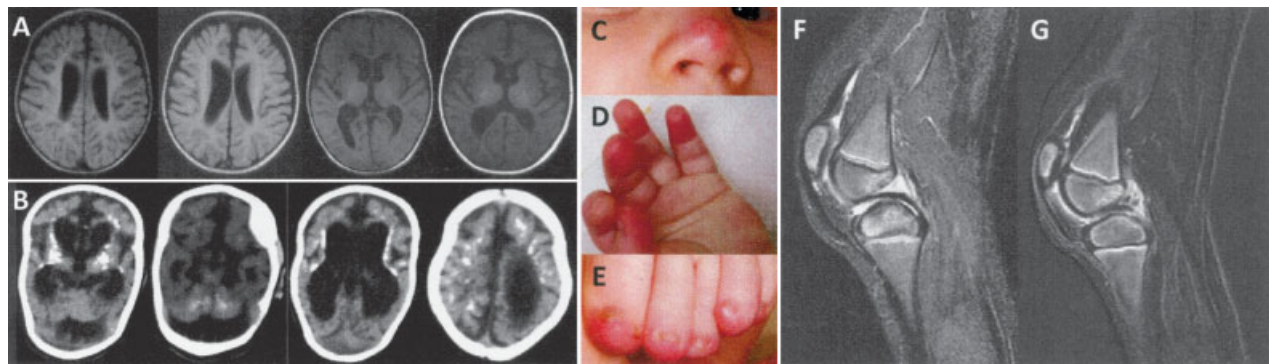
Imaging findings and cutaneous signs in patients with Aicardi-Goutières syndrome (AGS). A, Magnetic resonance imaging of an AGS patient with mutations in ribonuclease H2 subunit C (*RNASEH2C*)/AGS3 (patient 13), showing extensive white matter abnormalities with an anteroposterior gradient, in addition to cortical atrophy. B, Computed tomography imaging of an AGS patient with *RNASEH2A*/AGS4 (patient 16), demonstrating marked brain atrophy with prominent cerebellar atrophy, as well as symmetric calcifications of the basal ganglia and periventricular region extending throughout the cerebrum. C–E, Typical chilblain lesions on the nose, fingertips, and toes of an AGS patient with a heterozygous de novo 3'-repair DNA exonuclease 1 (*TREX1*) mutation (patient 6), presenting as painful erythematous swellings. F, Sagittal STIR sequence through the left knee of an AGS patient with mutations in sterile alpha motif domain and HD domain-containing protein 1 (*SAMHD1*)/AGS5 (patient 18), showing effusion and thickened synovia without surrounding soft tissue edema or bone erosion. G, Subtracted T1-weighted scan, after contrast media application, of the left knee of an AGS patient with *SAMHD1*/AGS5 (same patient as in F), showing marked contrast enhancement of the synovia, especially adjacent to the posterior cruciform ligament, indicating features compatible with a diagnosis of nonerosive arthritis.
